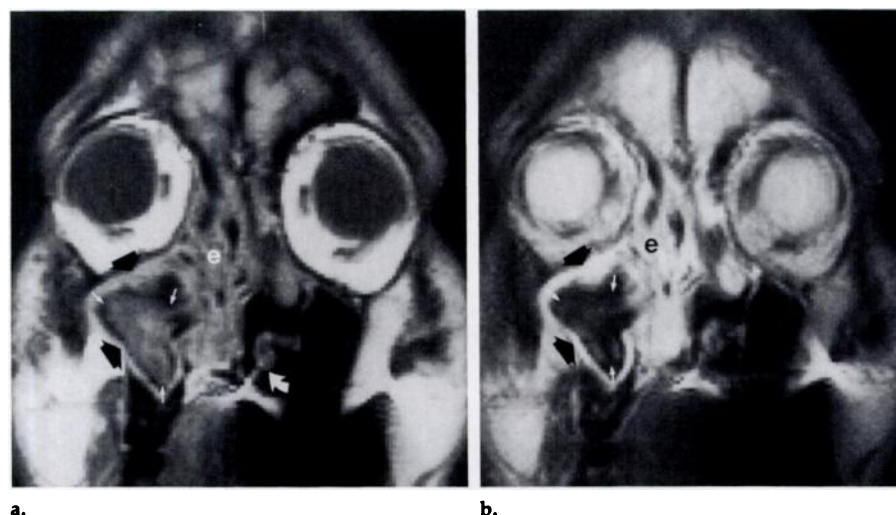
Fungal maxillary sinusitis compounding chronic pansinusitis. (a) Coronal T1-weighted MR image through the anterior ethmoid sinus depicts a soft-tissue mass in the anterior ethmoid sinus (e) isointense with contralateral inferior turbinate mucosa (curved arrow). Mucoperiosteal thickening (black arrows) along the bone wall of the right maxillary sinus has a similar isointensity. A soft-tissue hypointense mass (white arrows) occupies the center of the right maxillary sinus. (b) Coronal T2-weighted MR image demonstrates characteristic increased signal intensity of ethmoid sinus inflammation (e) with similar hyperintensity in the mucoperiosteal thickening (black arrows) of the maxillary sinus. The soft-tissue mass (white arrows) located centrally in the maxillary sinus has a much lower signal intensity than demonstrated on the T1-weighted image. Surgical-pathologic finding: aspergilloma.
